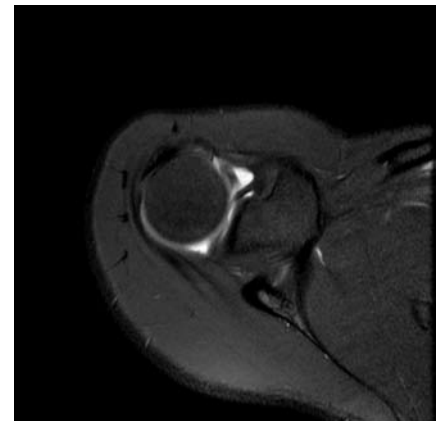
Axial MRI demonstrating tear of the superior labrum from the anterior to the posterior direction consistent with a type II tear.
